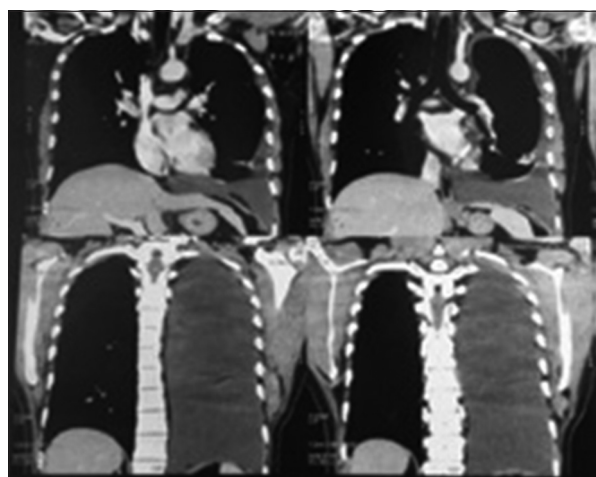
Computed tomography chest showing the left effusion with no residual mass in posterior mediastinum
